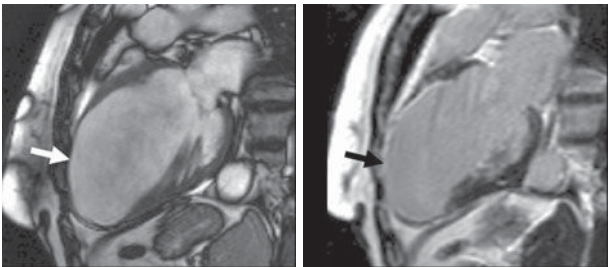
Cardiac MRI following acute antero-apical MI. Note thinning of the LV anterior wall and apex (left, white arrow). Blood within the heart appears white on this still from a cine image. Right: delayed gadolinium enhancement imaging shows the full extent of the infarcted tissue—infarcted myocardium appears white (black arrow).
